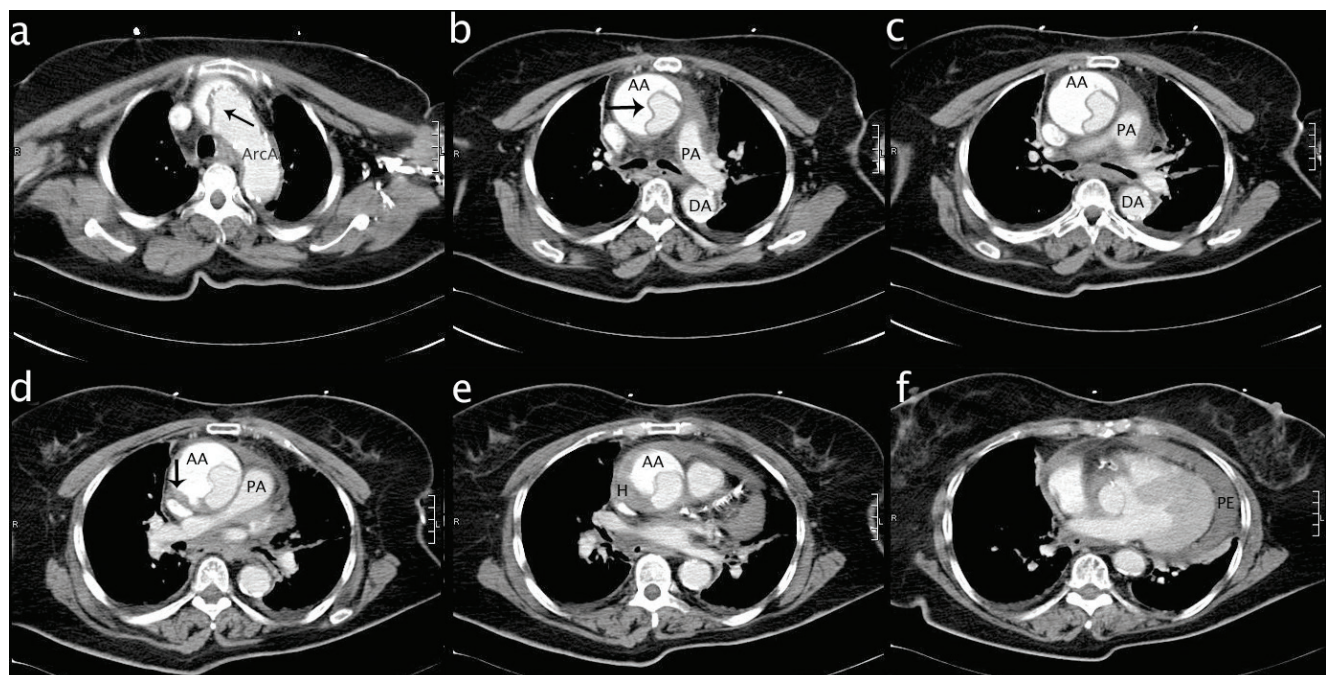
Computed tomography views of the patient.
